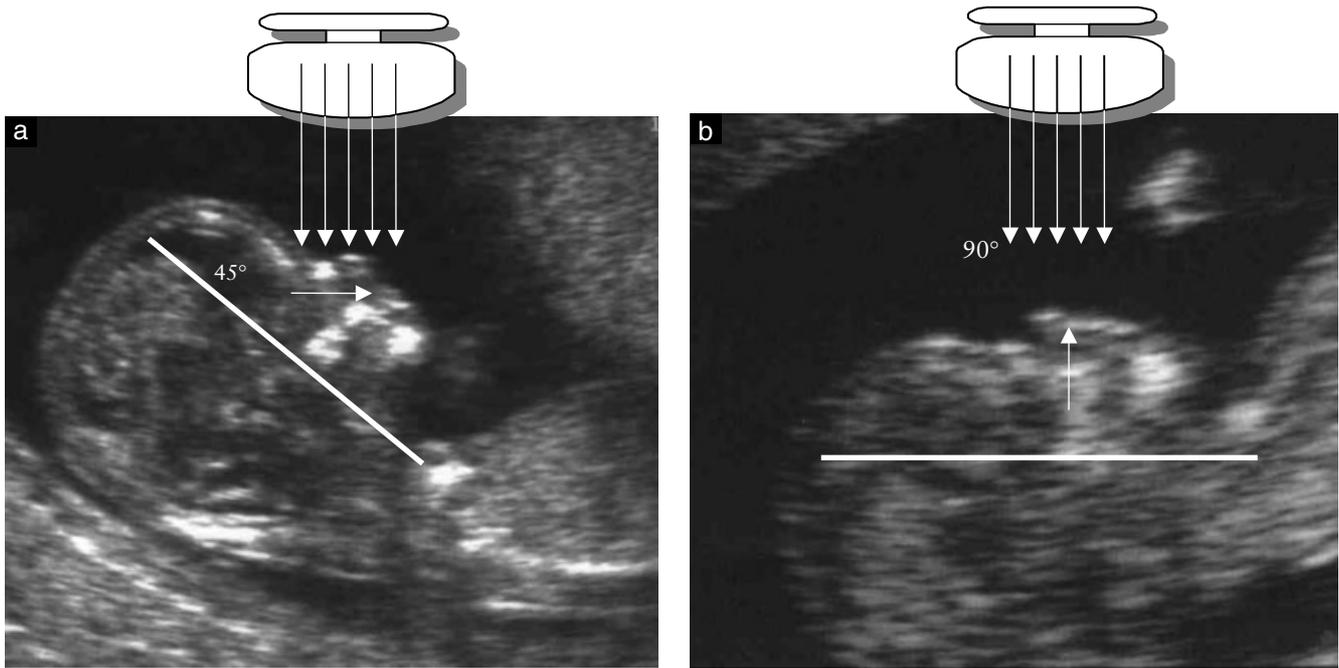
Ultrasound images demonstrating appropriate examination of fetal nasal bone: the angle between the ultrasound transducer and an imaginary line passing through the fetal profile should be about 45° (a) rather than 90° (b).
